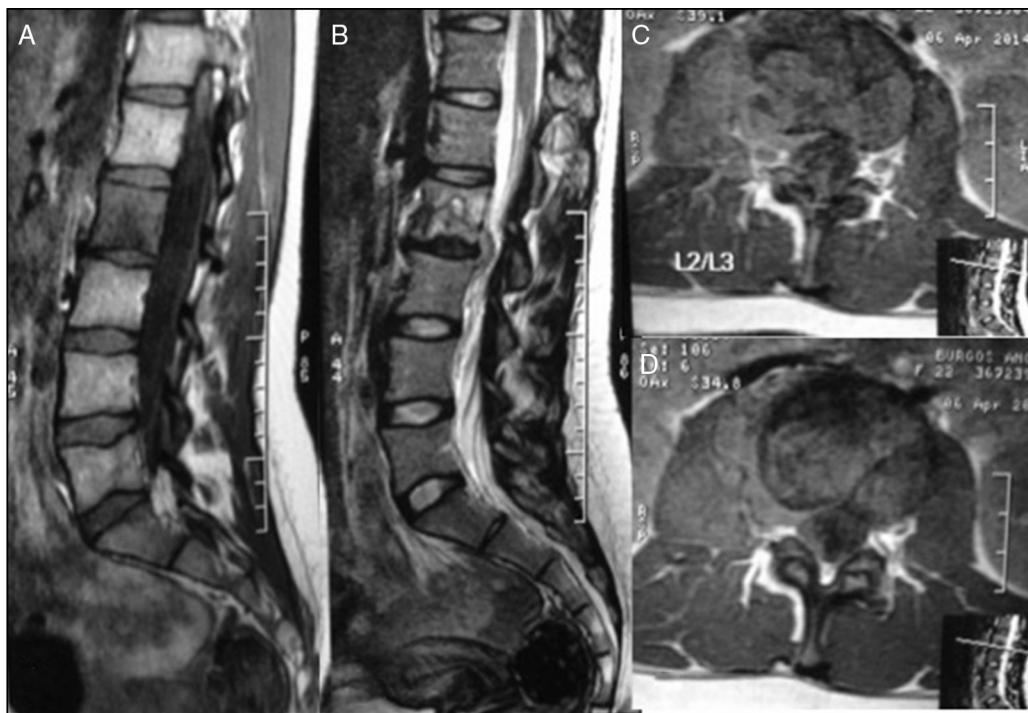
(A) and (B) T1-T2 sagittal MRI showing L2-L3 compromise; (C) and (D) Axial MRI showing right psoas muscle compromise.
